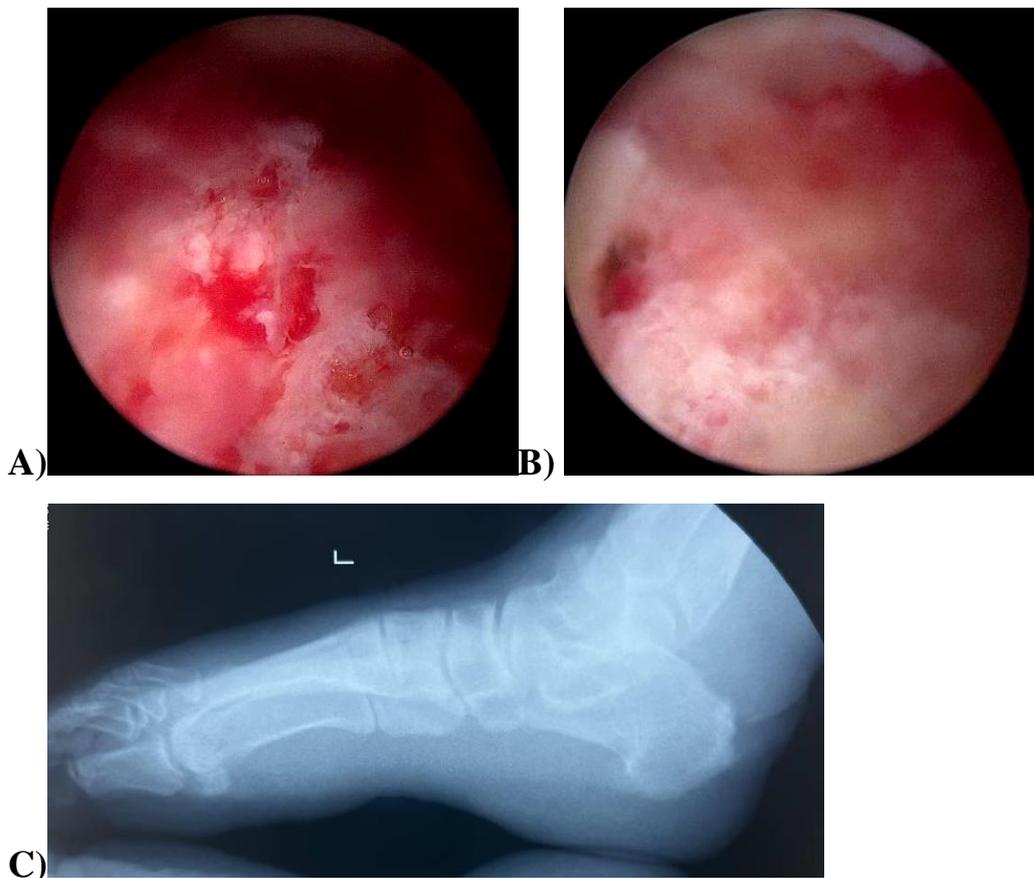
Haglund's deformity after resection. A) Endoscopic view of deformity, B) Endoscopic view after resection, C) X-ray image after resection.
